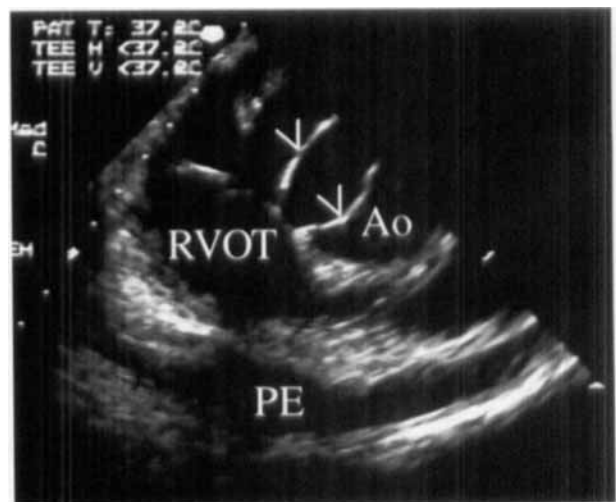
Transesophageal echocardiogram in Case No. 1: Longitudinal plane, showing bicuspid aortic valve (arrowheads), with right ventricular outflow tract (RVOT) and pericardial effusion (PE) beneath.
